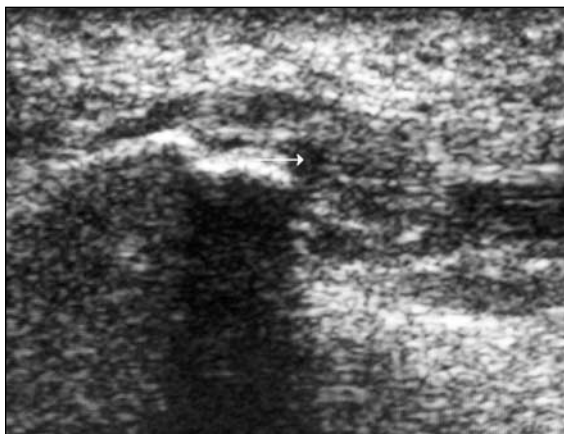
Sagittal heel sonogram from a 39-year-old man showing enthesopathic changes as a grossly thickened hypoechoic plantar fascia measuring 8.1 mm with loss of edge sharpness.
